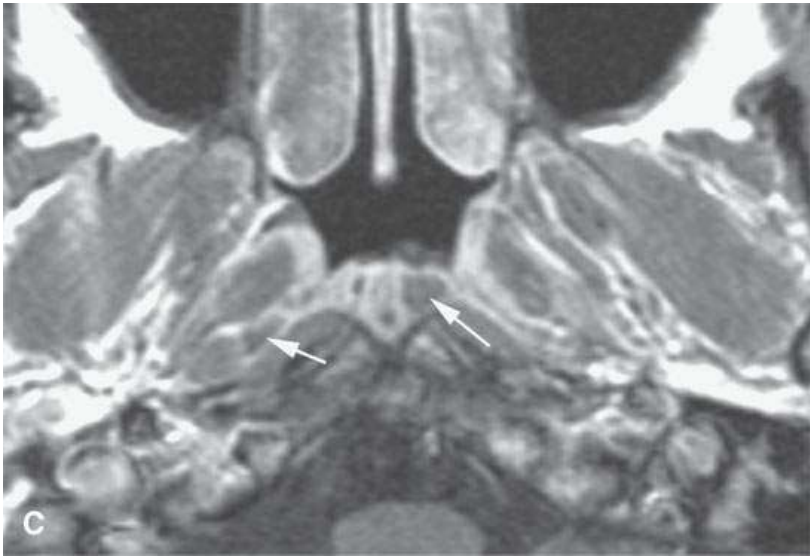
Magnetic resonance imaging of incidental and clinically insignificant retention or postinflammatory cysts in the adenoids. A: On T1-weighted images, the cysts are isointense to the normal lymphoid tissue. B: On T2-weighted images, the cysts become far more conspicuous (*arrows*). C: Contrast-enhanced T1-weighted images shows the cysts differentiated from the normally enhancing lymphoid tissue (*arrows*).
